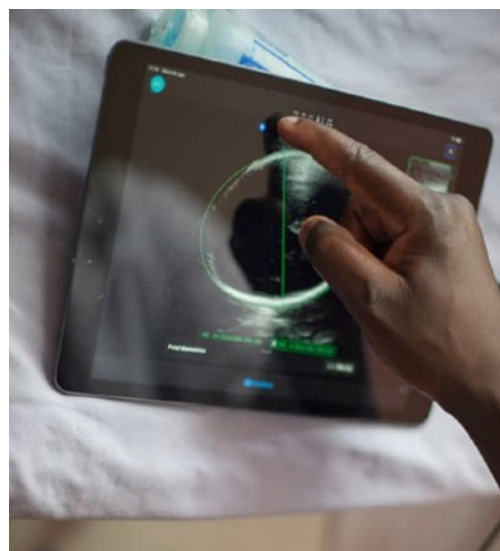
Large Orbital Mass with delineation and 3D configuration extended to extraconal space using Butterfly IQ+ Handheld Ultrasound. (Same lesion shown in B scan for comparison).
